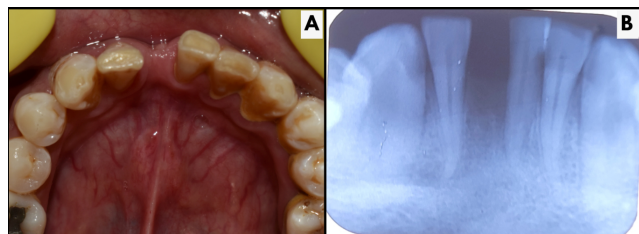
A): Intraoral mandibular view showing missing left central incisor, B): Intraoral Periapical view radiograph showing healthy abutment teeth.
